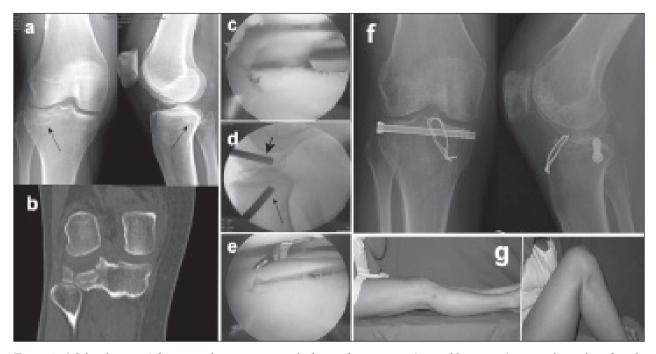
a) Schatzker type 3 fracture with a concomitant tibial spine fracture in a 45-year old woman. Arrows indicate the inferiorly displaced articular fragment. b) Coronal CT scan highlighting the depression of the articular surface. c) Arthroscopic view of the lateral knee compartment before ARIF. d) Intraoperative fluoroscopy to check the correct position of the impactor in elevating the depressed bone fragment. The thin arrow indicates the impactor and the large one points the arthroscope. e) Arthroscopic view showing restoration of the articular surface of the lateral tibial condyle after ARIF. f) Radiographic control 3 months after surgery showing the good anatomical result. Wire cerclages were used to treat the tibial spine fracture. The patient suffered joint stiffness and underwent two subsequent arthroscopic arthrolysis. g) Final knee ROM one year after index procedure: extension was not fully recovered.
